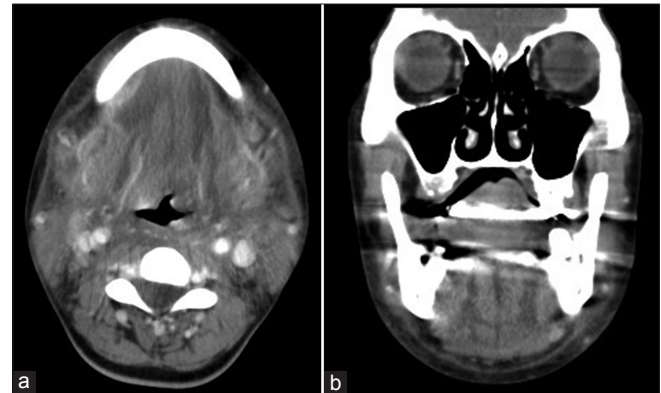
Contrast-enhanced computed tomography of the neck (a) showed diffuse soft-tissue swelling and fatty stranding of the sublingual, submental, and submandibular areas, and the rest of bilateral cervical spaces; (b) swelling of submandibular space resulted in an upper elevation of the tongue and consequently caused pending upper airway obstruction
